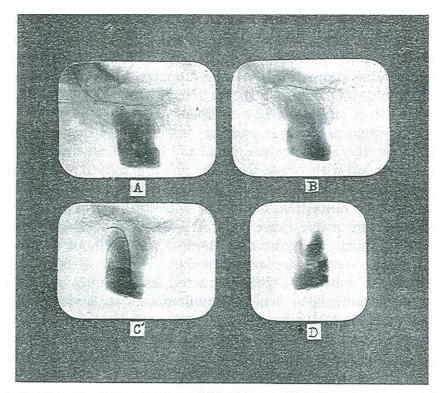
Roentgenographic studies of periodontoclasia: A and B, different angles; C, with flexible gutta-percha points; D, extracted tooth.
